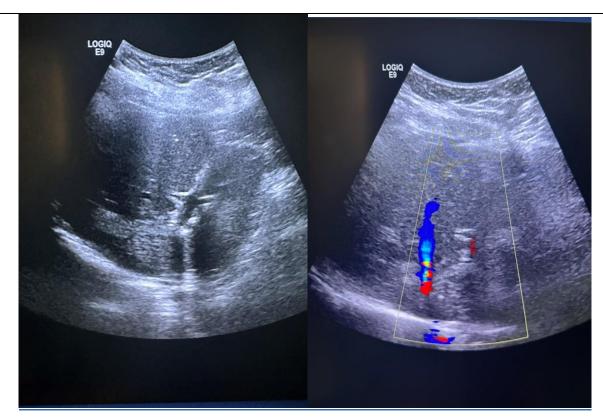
Hepatic Doppler ultrasound revealed Hydatid cyst invading segments IV et VIII of the liver close to the inferior vena cava.
